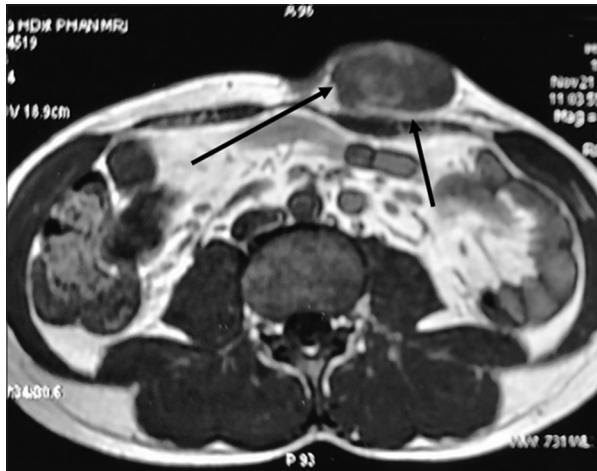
Magnetic resonance imaging (axial cut) showing a mass lesion in the subcutaneous plane of left paraumbilical region
